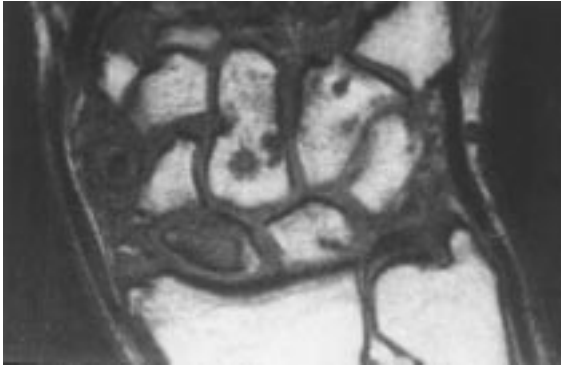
Magnetic resonance image demonstrates avascular necrosis of the proximal scaphoid fragment.
